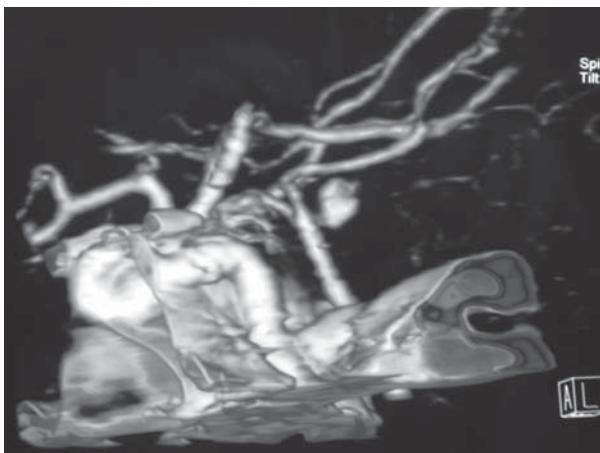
CT angiogram showing a pea-like aneurysm a short distance behind the basilar bifurcation and connected to it by a short stalk.
